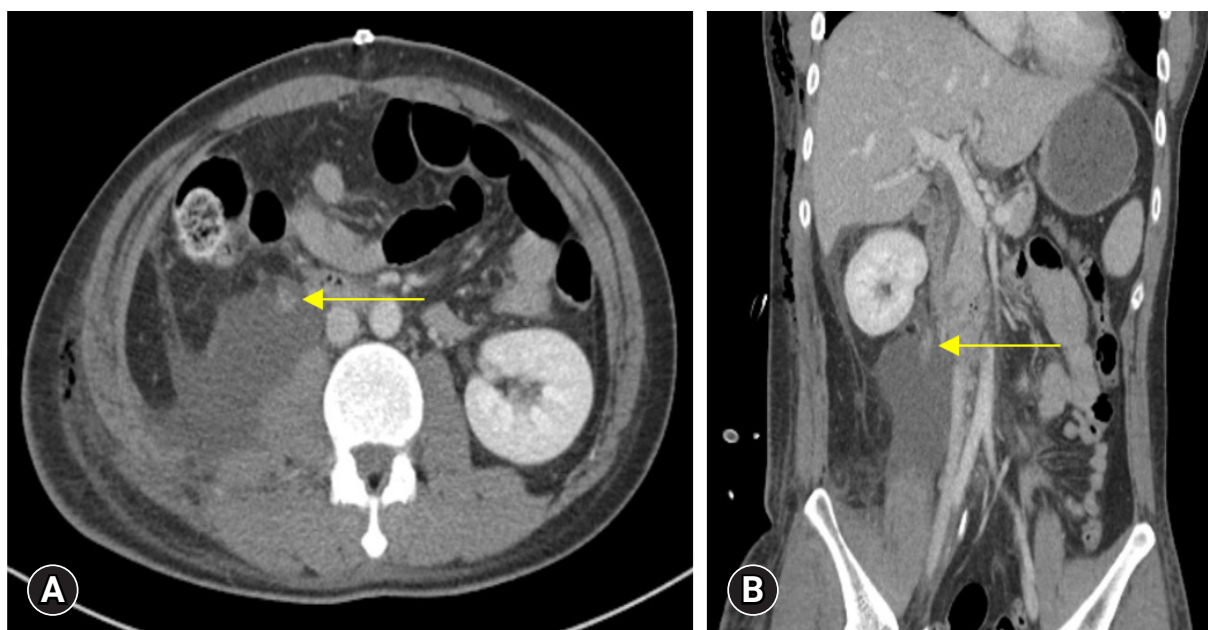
Computed tomography (CT) urography taken on postoperative day 8 with pre, arterial, portal, and delayed phases. (A) A 1-hour delayed axial view of the CT urography shows contrast retention in the right kidney in comparison to the left kidney (arrow). (B) A 10-minute delayed topogram of CT urography shows the intact left ureter as compared to the nonvisible right ureter with contrast media retained in the right kidney parenchyma (arrow).
